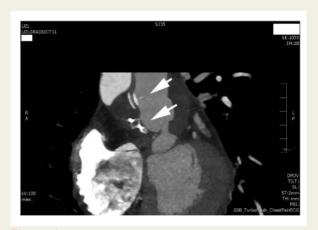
Contrast computed tomography demonstrating a complete occlusion of the pseudoaneurysm and a stable position of the two occluder devices (white arrows) 1 month after the procedure.
